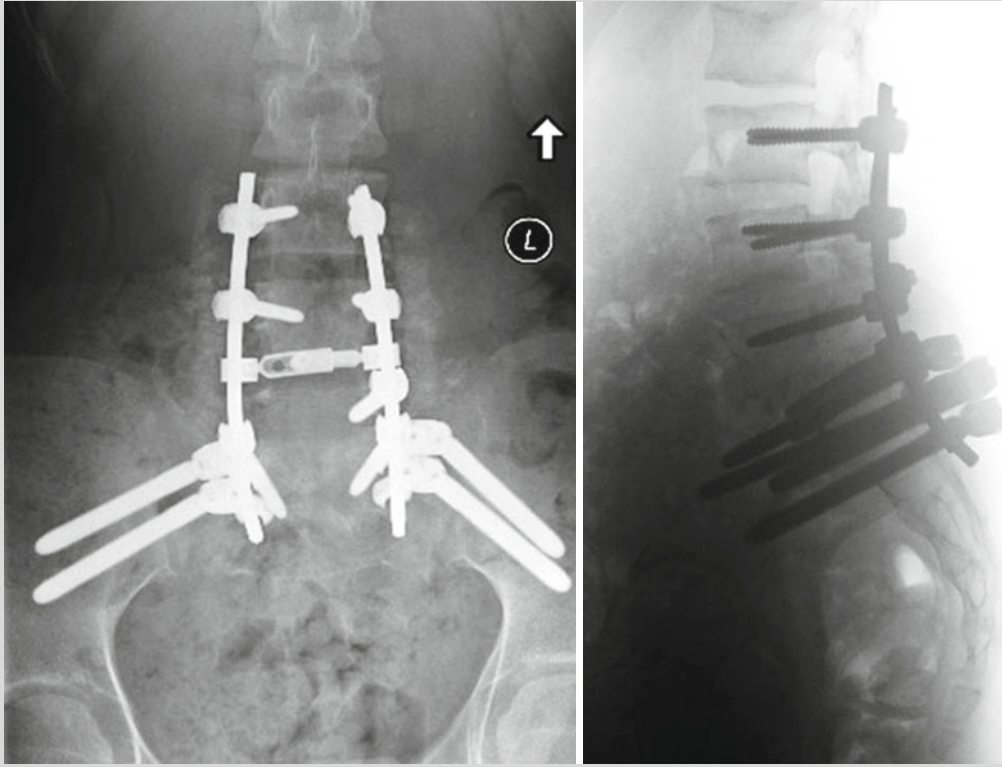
Postoperative anteroposterior and lateral X-rays following open reduction and internal fixation with instrumented L3 iliac posterior lumbosacropelvic
